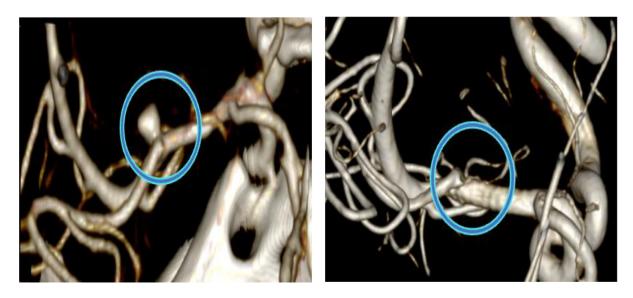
CTA results (left): saccular aneurysm at right MCA, cerebral angiography 1 month after CTA (right): no dome aneurysm visible, still visible aneurysm remnants resembling an aneurysm blister.
